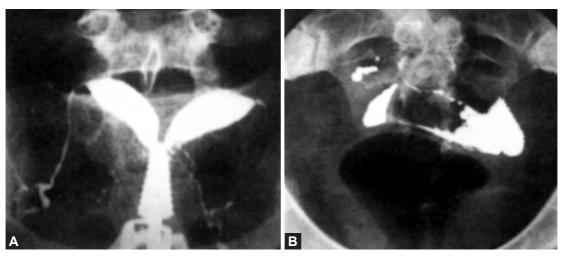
Hysterosalpingography showing both tubes obstructed at their outer ends and a uterine cavity which is slightly enlarged and irregular in shape as a result of small leiomyomas. The patient in this case complained of infertility and gave a history of contact with tuberculosis in adolescence. Tubal patency tests were therefore avoided until the endometrium was proved bacteriologically negative for this disease. Ultimately, however, tubercle bacilli were cultured from the tubes. (A) Radiograph at the time of injection shows dilated and closed outer ends of the tubes, (B) The medium is retained in the tubes 24 hours later
